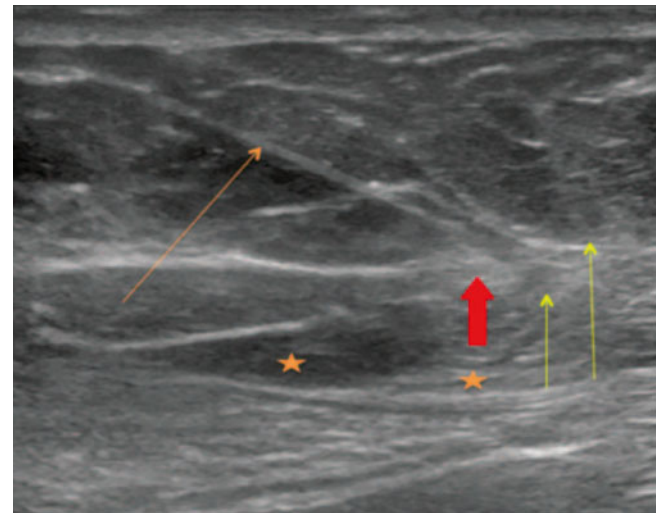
Ultrasound-guided 14-gauge angiocatheter insertion (*orange arrow*) for hydrodissection (*orange star*) of the iliohypogastric nerve (*red arrow*) with catheter insertion (*yellow arrow*) (Image courtesy of Adam Adler, MD, with permission)
